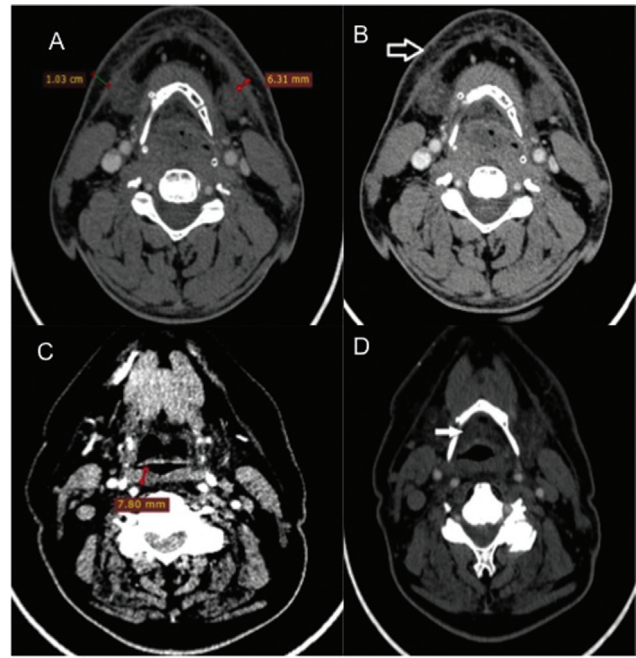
Expected postradiation changes. Axial sections of follow-up computed tomographic scan of patients at 3 months after completion of radiotherapy showing (A) thickening of skin and platysma, (B) reticulation of subcutaneous fat (arrow), (C) thickening (calipers) of pharyngeal wall, and (D) increased preepiglottic fat (arrow).
